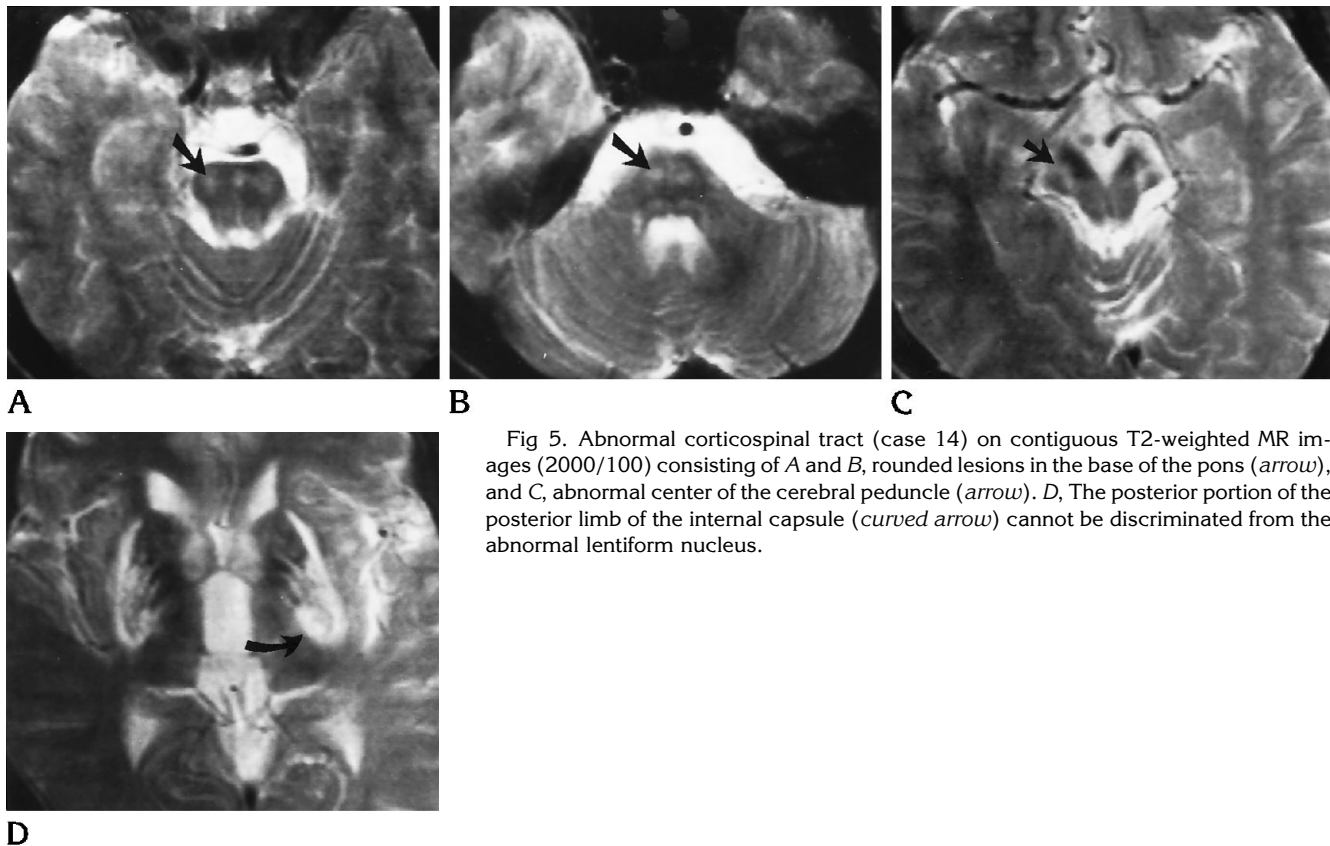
Abnormal corticospinal tract (case 14) on contiguous T2-weighted MR images (2000/100) consisting of A and B, rounded lesions in the base of the pons (*arrow*), and C, abnormal center of the cerebral peduncle (*arrow*). D, The posterior portion of the posterior limb of the internal capsule (*curved arrow*) cannot be discriminated from the abnormal lentiform nucleus.
